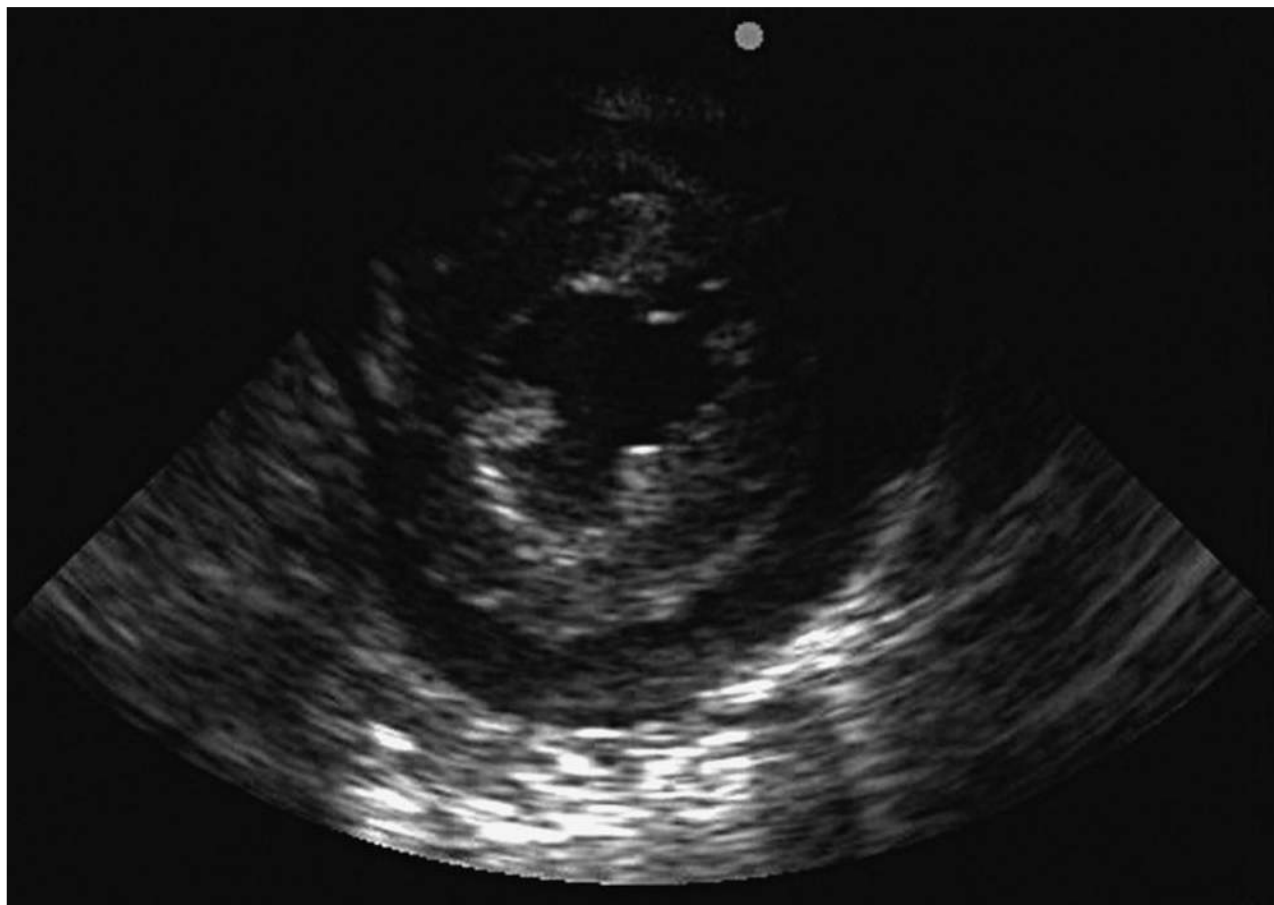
Parasternal, mid-papillary short-axis view of the left ventricle showing a large pericardial effusion with an anechoic fluid stripe circumferentially surrounding the heart.
